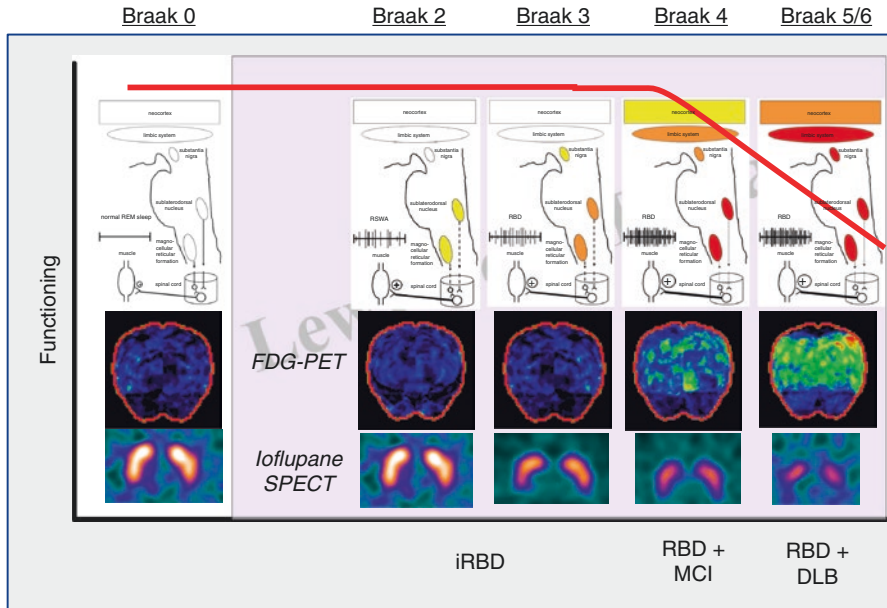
Electrophysiologic changes in REM sleep tone, the neurodegenerative changes according to the Braak staging system, and biomarker findings based on neocortical and nigral integrity along this clinical RBD-MCI-DLB continuum. Braak Stage 0 is not associated with any clinical symptoms nor Lewy body pathology. Degenerative changes in Stage 2 would involve the sublateralodorsal nucleus and magnocellular reticular formation and potentially result in mild REM sleep without atonia but perhaps minimal if any dream enactment behavior. Overt RBD would be predicted by Stage 3, and sufficient degenerative changes may be present in the substantia nigra that could be reflected on ioflupane SPECT, but no overt parkinsonism would be evident yet. The limbic and neocortical structures are spared, and therefore FDG-PET should still show normal metabolism. Cognitive changes and associated occipital hypometabolism may be evident in Stage 4, and overt cognitive impairment plus parkinsonism would be expected in Stages 5 and 6 with corresponding changes on FDG-PET and ioflupane SPECT. Importantly, many MCI patients and a significant minority of DLB patients do not have any degree of parkinsonism early in the course, and even despite overt RBD, the findings on ioflupane SPECT may be normal. This suggests that the MCI and DLB phenotypes are associated with relative sparing of the substantia nigra in a minority of patients, and hence the classic Braak staging system may not be consistently applicable to all patients in the evolution of RBD to MCI to DLB
